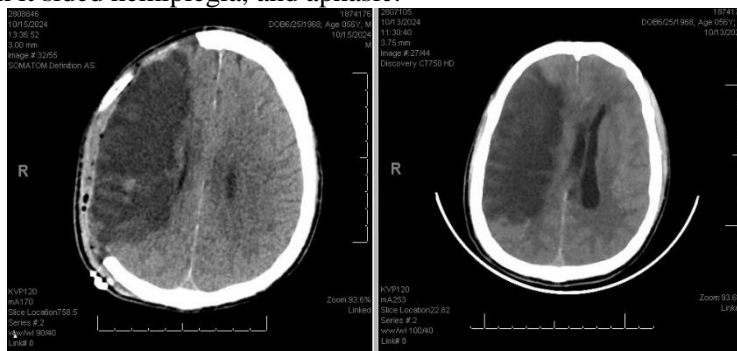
showing pre op intracerebral hematoma with brain edema, midline shift (RT CT axial cut), and post decompressive craniectomy (LT CT axial cut).
